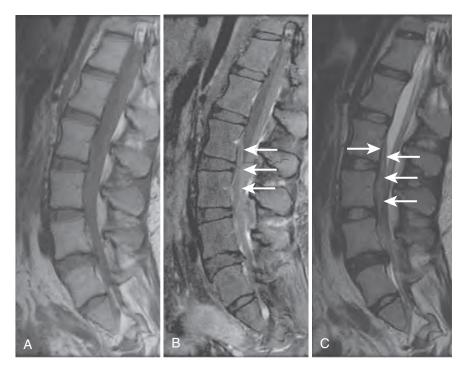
Precontrast (A) and postcontrast (B) T1-weighted sagittal images demonstrating rimenhancing soft tissue in the ventral and dural epidural space (arrows), consistent with epidural abscess. (C) T2-weighted sagittal image demonstrating compression of the thecal sac (arrows). (Courtesy Stanley Lu, MD, Monmouth Medical Center, Long Branch, NJ.)
